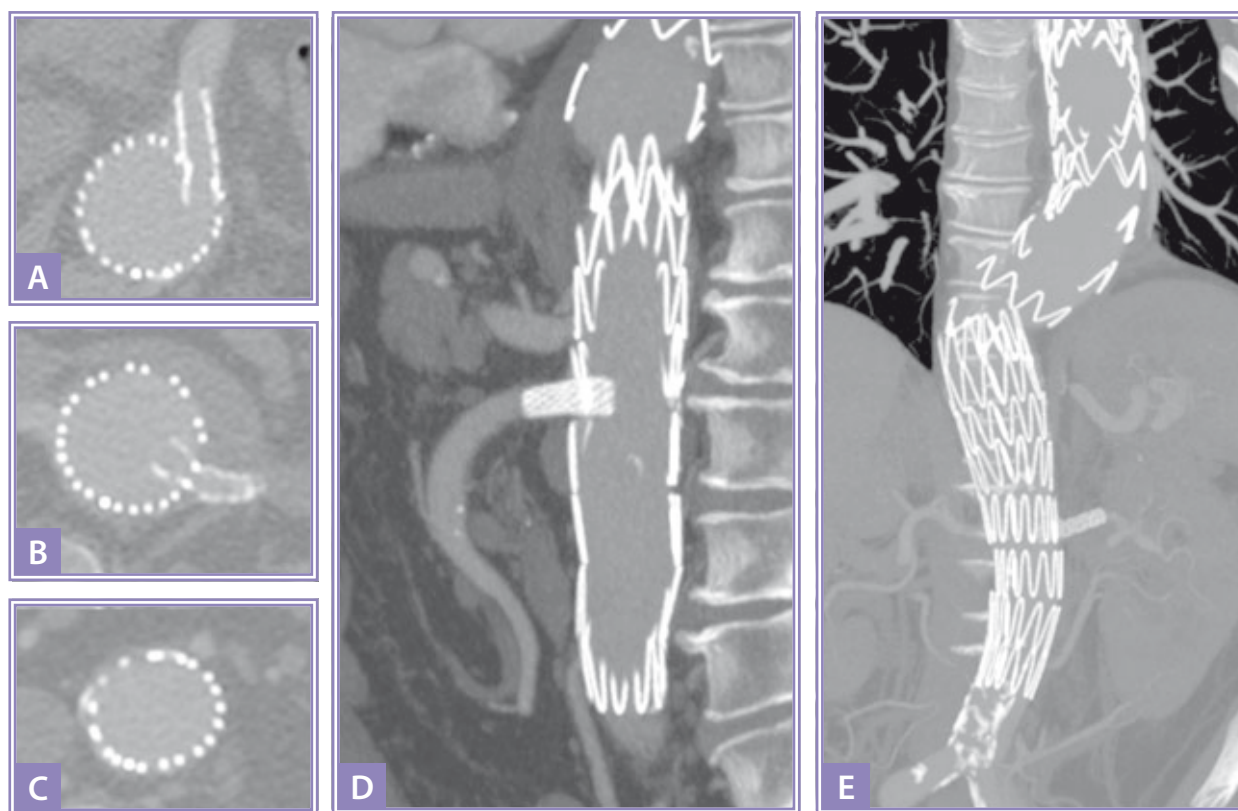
A follow-up CT scan showing (A) obliteration of the FL and patency of a stent placed in the superior mesenteric artery, (B) obliteration of the FL and patency of a stent placed in the left renal artery, (C) complete obliteration of the FL at the level of the abdominal aorta, (D) 3D reconstruction showing the obliteration of the FL and patency of a stent placed in the superior mesenteric artery, and (E) 3D reconstruction showing the obliteration of the FL and patency of a stent placed in the left renal artery.
